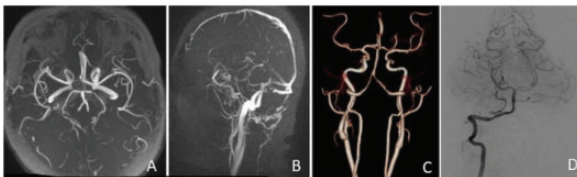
Vessel imaging. A-MR-angiogram, B-MR-venogram, C-CT-angiogram, D-Digital subtraction angiogram
